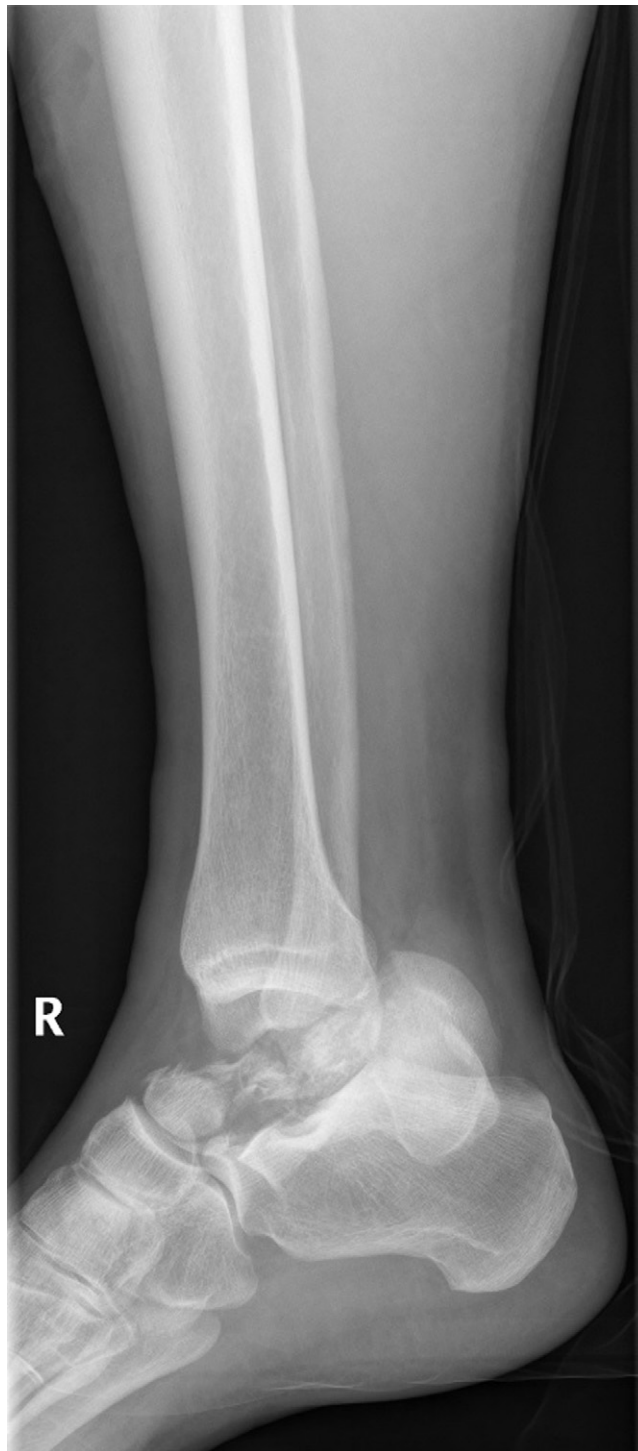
X-ray of a right ankle: Hawkins IV talar neck fracture with complete dislocation of the corpus.
